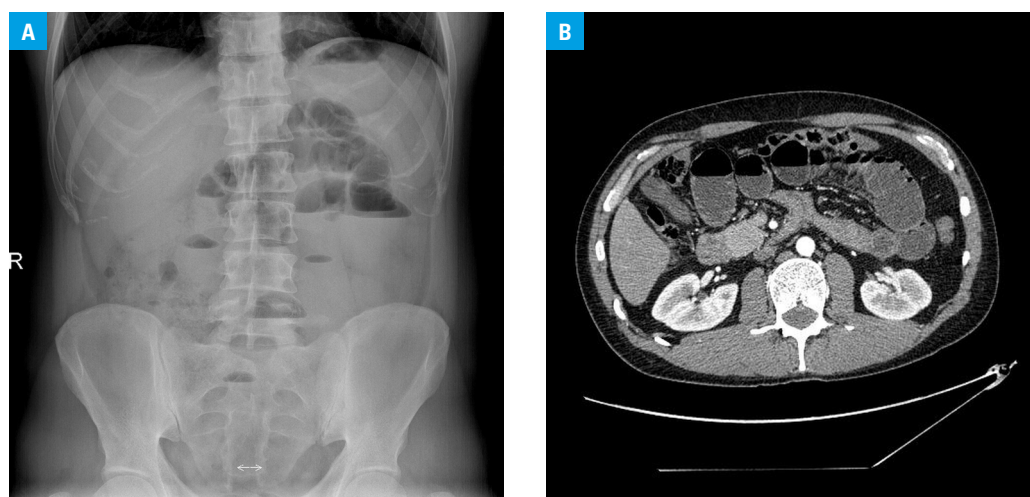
A – standard posteroanterior vertical abdominal X-ray showing gas-fluid levels in the small bowel loops in the epigastrium; B – computed tomography visualizing gas-fluid levels in the herniated loops in the epigastrium
